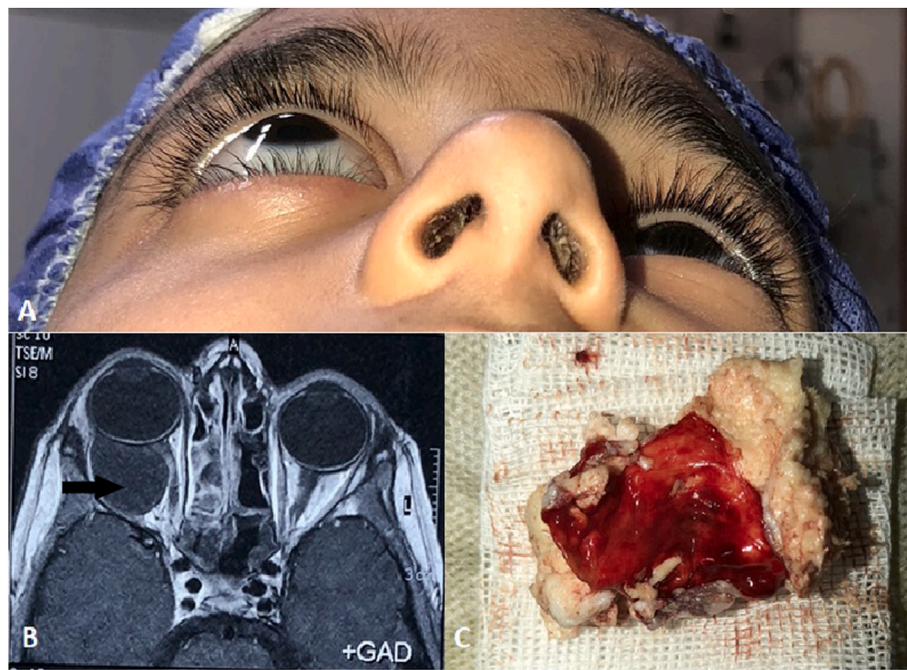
8-Year-old girl with intraconal epidermoid cyst (Case NO.1). A: Clinical image of the patient presented with right proptosis (worm’s-eye view). B: Axial contrast-enhanced magnetic resonance imaging (MRI) shows a well-defined mass with ring enhancement on the right orbit. C: Photograph of gross pathology after complete removal of mass via transconjunctival approach.
